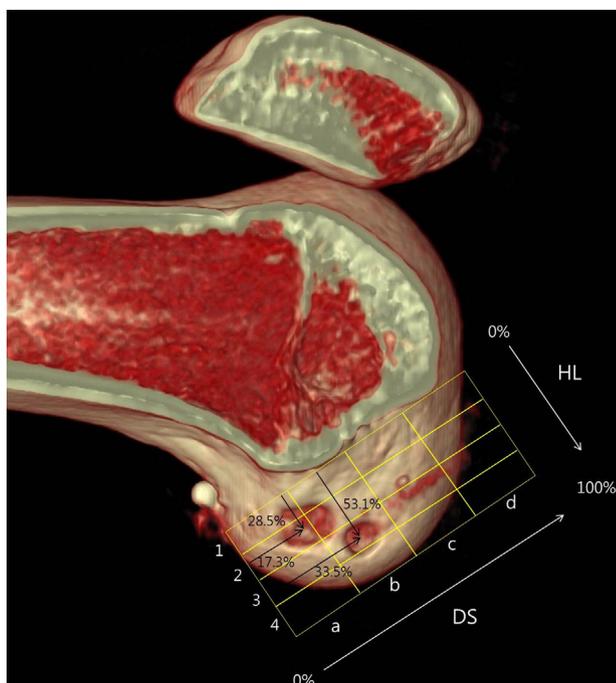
Center locations of the anteromedial and posterolateral femoral tunnels. The percentage distance of each tunnel was measured from the most anterior edge of the femoral notch roof and the most proximal line of posterior femoral condyle on three-dimensional computed tomography, using the quadrant method. The tunnel positions were determined in the anterior-posterior position, perpendicular to the Blumensaat's line, and in the proximal-distal position, parallel to the Blumensaat's line.
